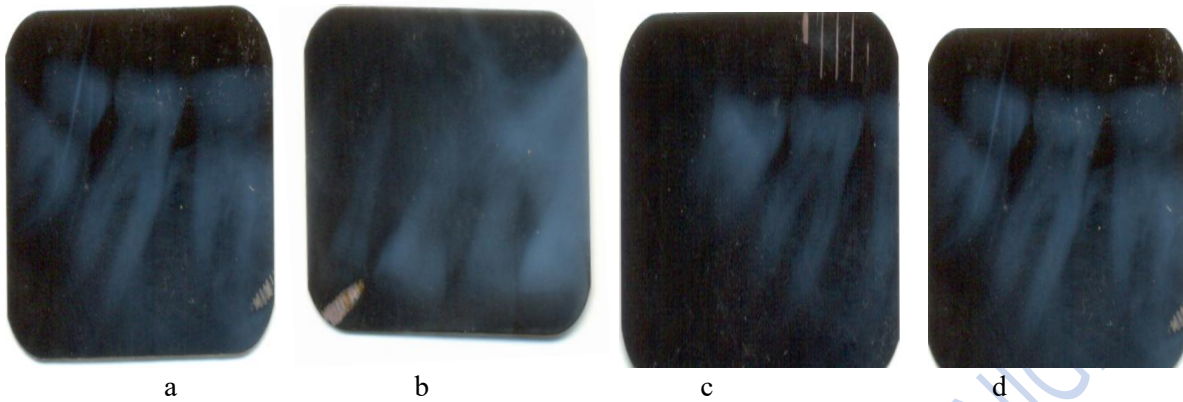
a-d cropped images of periapical radiographs
